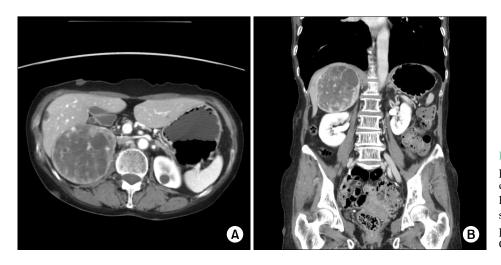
Radiologic appearance of pheochromocytoma. Abdominal computed tomography scan shows large, well-defined, heterogeneously enhancing mass at right retroperitoneum. (A) Axial view. (B) Coronal view.
